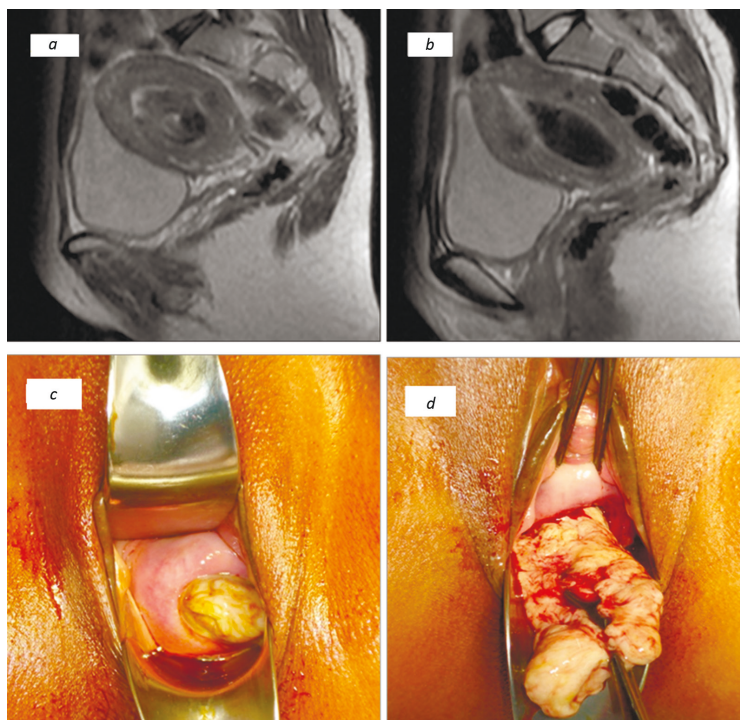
MRI of the woman's pelvis sagittal projection (a, b) and operation photo (c, d)
